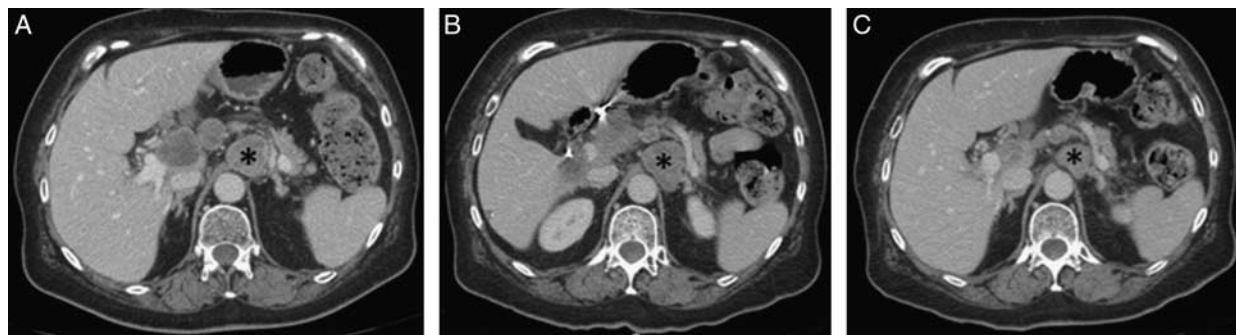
Case 2 CT scans over treatment course. A, CT on the start of dual immunotherapy initiated demonstrates multiple enlarged celiac axis lymph nodes, with index lymph node (black *) measuring 32 mm in short axis. B, Three months CT into dual immunotherapy, index lymph node demonstrated a mild increase in the size of 34 mm (black *). C, Despite slight enlargement of lymph nodes, dual immunotherapy was continued as other clinical markers improved, and 6-month follow-up demonstrated decrease in the size of index lymph node to 24 mm, suggesting prior enlargement may have been pseudoprogression.
